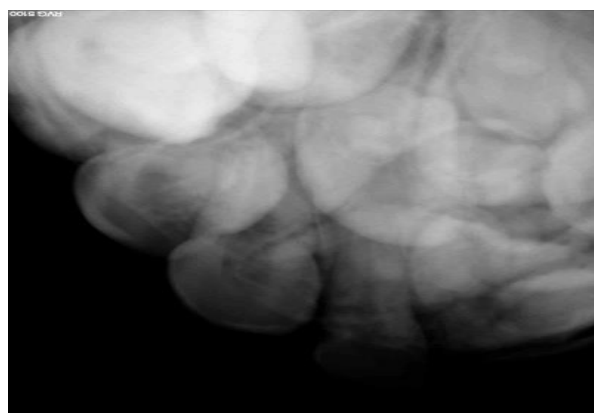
Intraoral periapical radiograph showing a calcified dental tissues, located in the maxillary right anterior region
